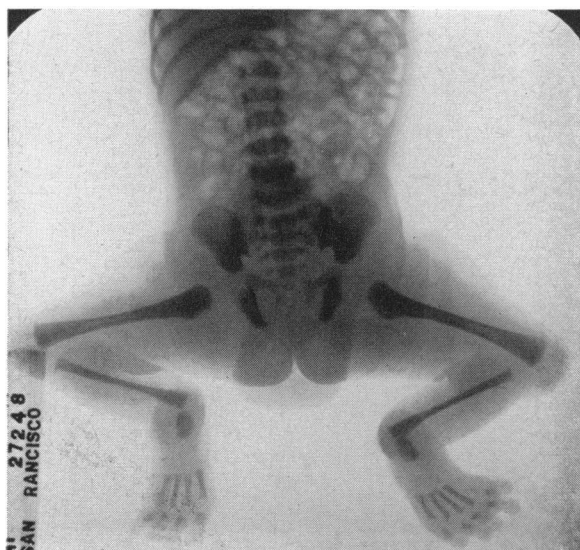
Roentgenogram of newly born infant. The bilateral posterior dislocation of the tibiae is pronounced.
